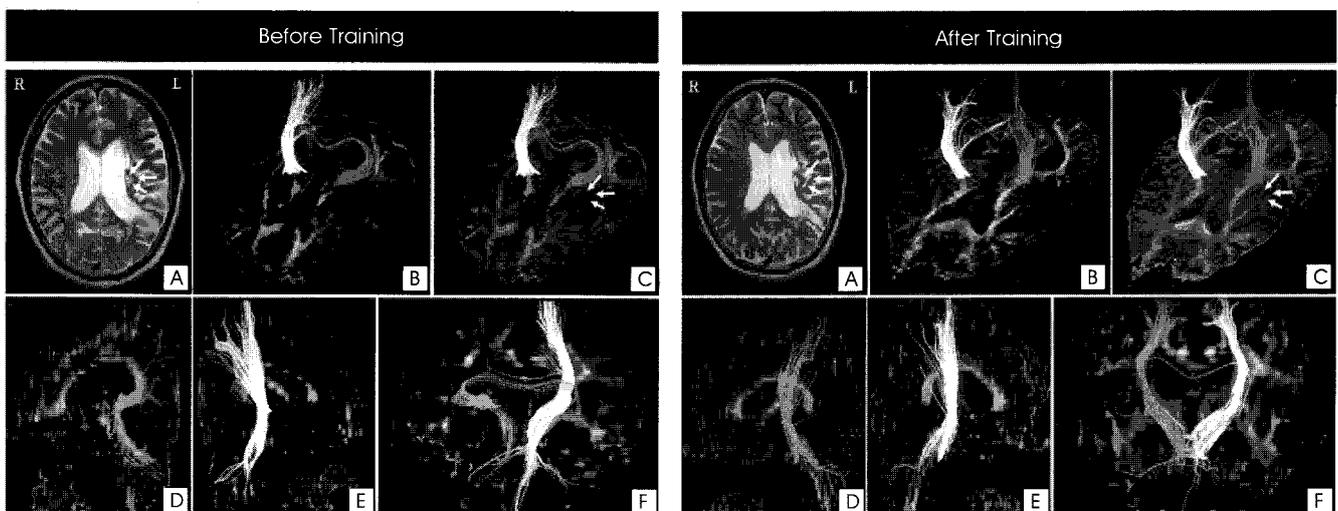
Tractography in Patient 5, A: axial T2-weighted image, B: 3D tractography superimposed on an axial color map, C: 3D tractography superimposed on an axial FA map, D: 3D tractography superimposed on a left sagittal color map, E: 3D tractography superimposed on a right sagittal color map, F: 3D tractography superimposed on a coronal color map. Corticospinal tract of the affected side: red lines, unaffected side: yellow lines
